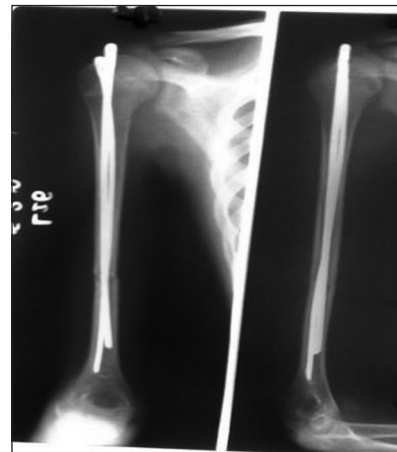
Post-op radiograph of fracture shaft of humerus
